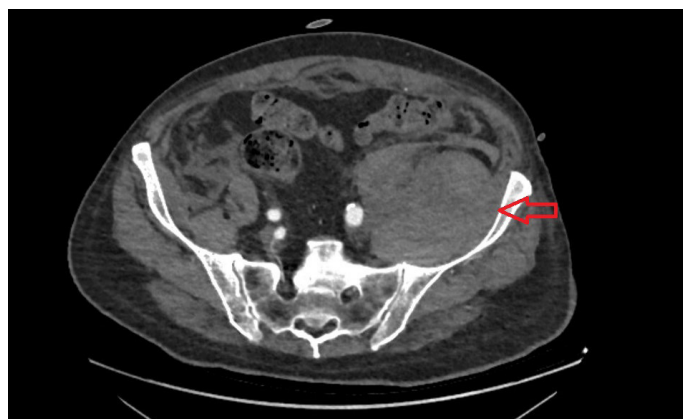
The arterial phase CT imaging of the retroperitoneal bleeding
